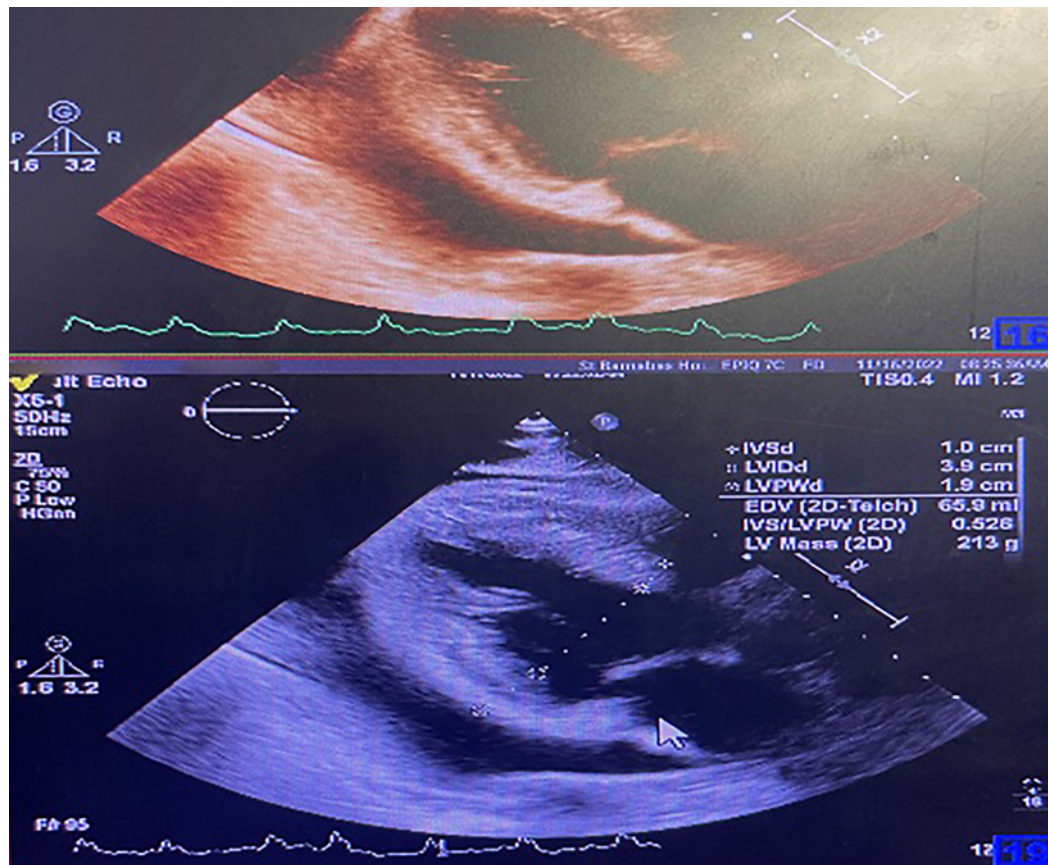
Echocardiogram showing a large PerF collapsing the right atrium, an ejection fraction of 56%, and moderate left ventricular hypertrophy.
